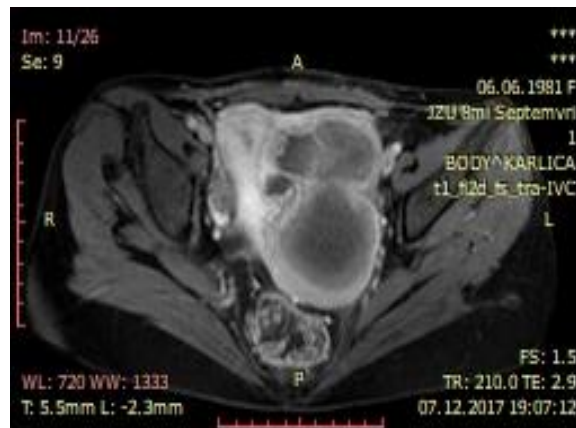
One and a half month post embolisation T1 FS contrast-enhanced axial MRI of the uterus in the same patient shows complete necrosis of both fibroids (arrow) and preservation of uterine body wall with normal enhancement
